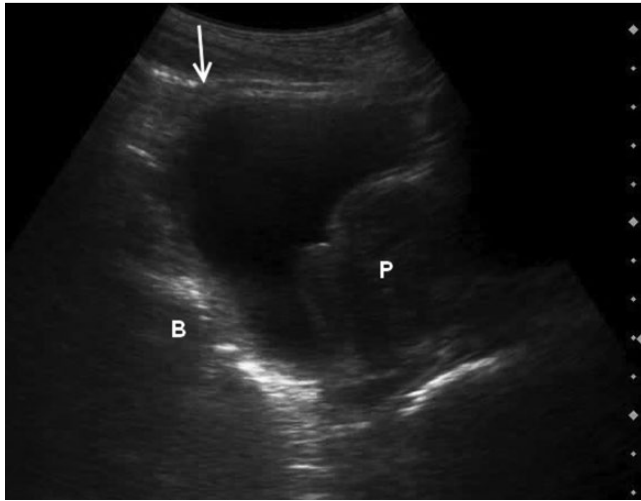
Sonographic views of the bladder. The transverse view (a) shows the two rectus abdominis muscles (r) and the intervening linea alba (arrow). The seminal vesicles (S) can also be seen. (b–d) show sagittal views of the bladder. The point at which the peritoneum reflects from the anterior abdominal wall onto the dome of the bladder is shown by the vertical arrow in panels (b) and (c). The reflection is cephalad to the scanning plane in panel (d). Properitoneal fat (F) sometimes extends to the dome of the bladder (B), as in (b). An enlarged prostate (P) can be seen in (c) and (d).
